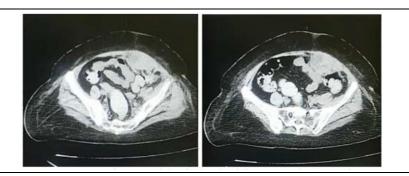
Abdominal and pelvic computed tomography scan
